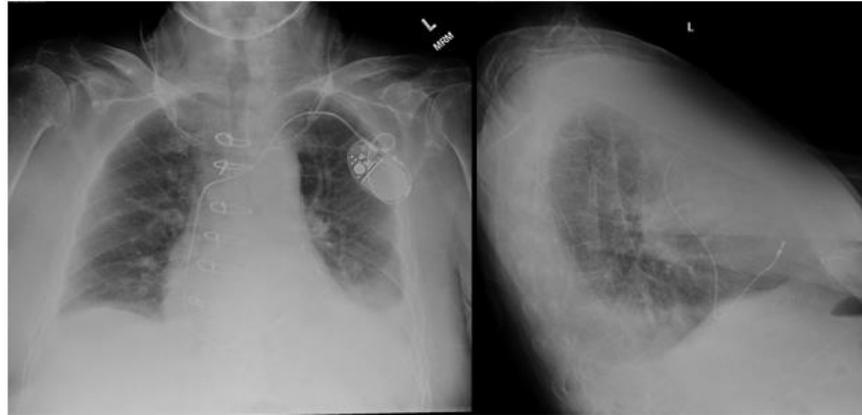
Posteroanterior (PA) and lateral chest radiography demonstrating a left-sided pleural effusion. Image courtesy of Abdelkader Mallouk, Radiopaedia.org, rID: 71570.
